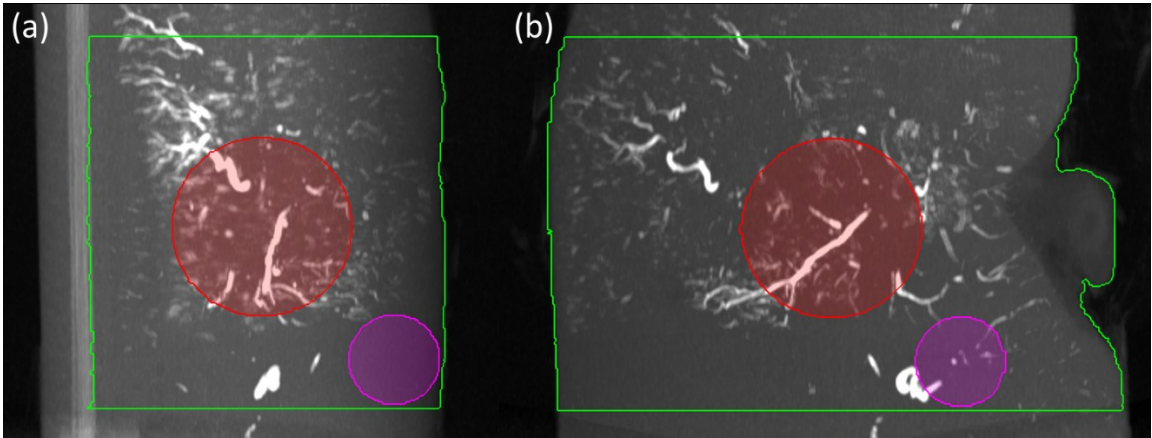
VOIs within the kidney shown on a μ CT maximum intensity projection [HU: -1000 to 5000]: Red – target, Magenta – normal tissue, Green – whole-body. (a) Sagittal view. (b) Coronal view. The apparent presence of embolized tissue within the normal tissue is due to the projection of the 3D VOI onto a 2D plane.
